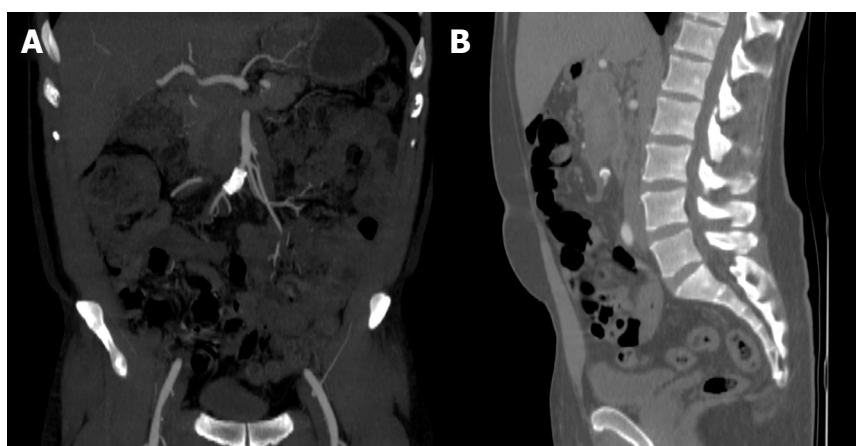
Postoperative surveillance CTA demonstrated successful exclusion of the SMAVF and loss of venous collaterals on both coronal (A) and sagittal (B) projections. CTA: computed tomographic angiogram; SMAVF: superior mesenteric arteriovenous fistula
